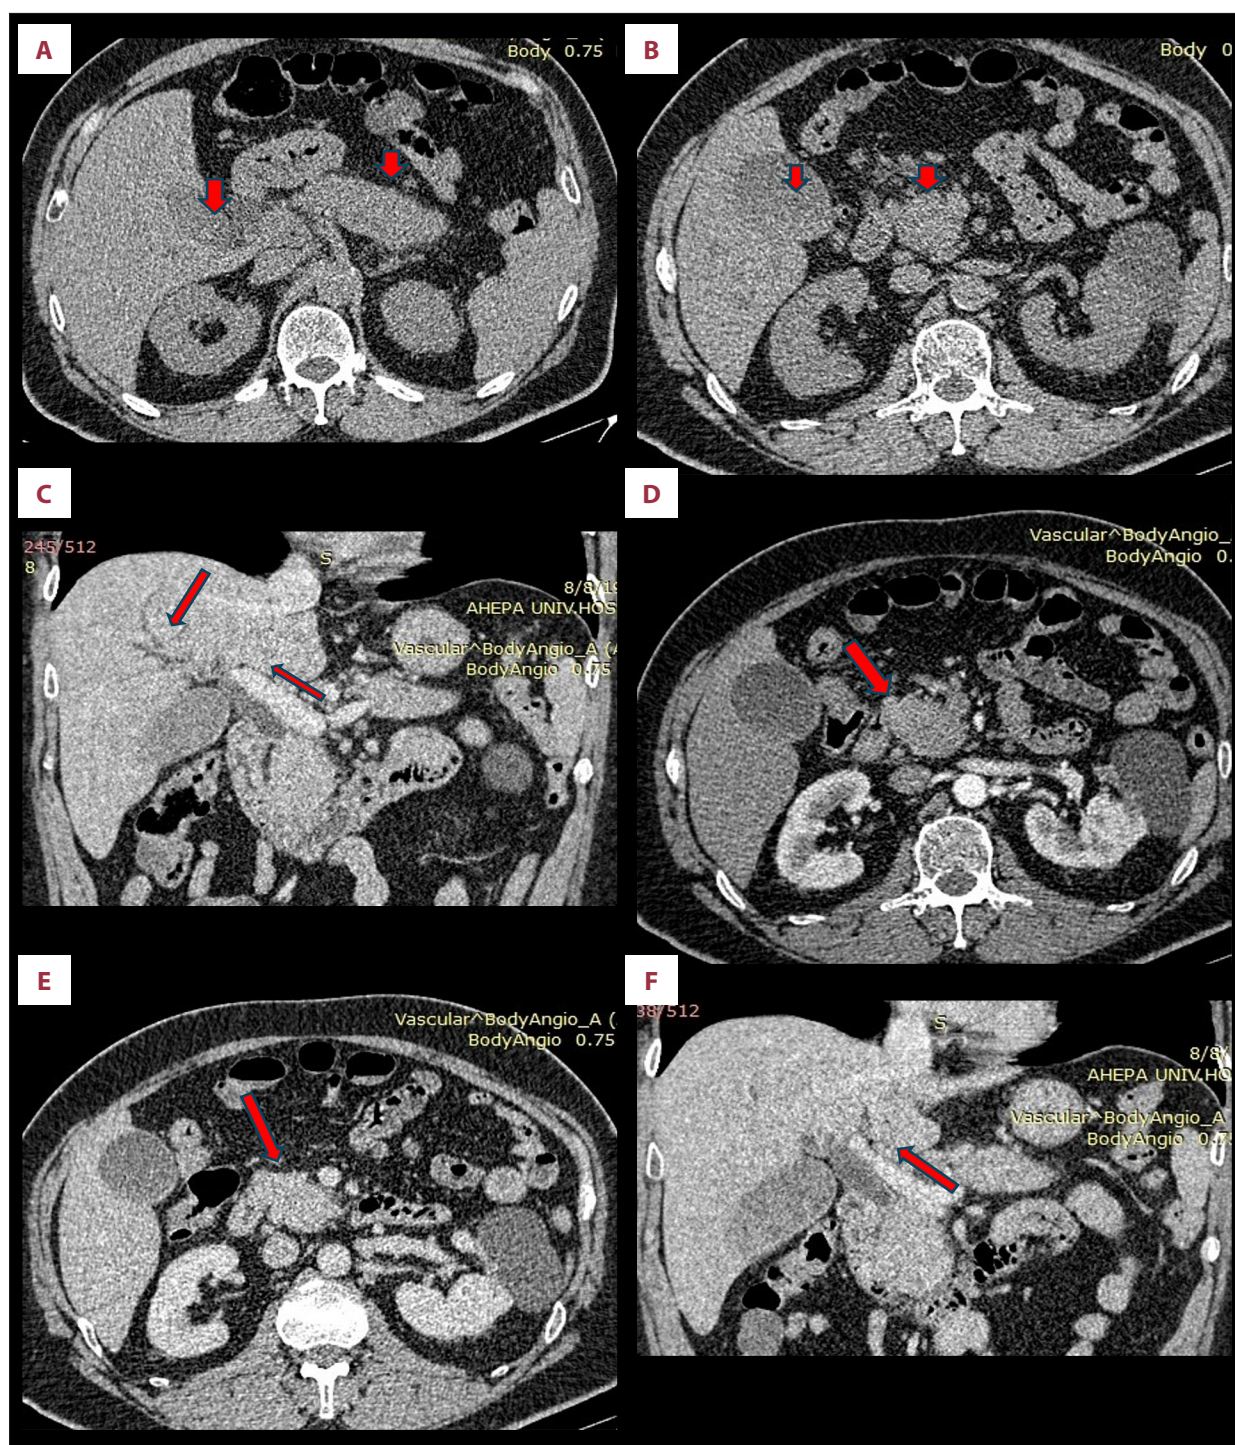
Detailed CT scan imaging characteristics of pancreatic enlargement and inflammation. (A, B) NECT axial images: Diffuse enlargement of the pancreas, especially of the head, with poorly-defined borders. Hyperdense content in the gallbladder. (C, D) CECT late arterial/portal venous phase; axial images: Heterogeneous attenuation of the head of the pancreas. Pancreatic inflammation is mainly localized to the area adjacent to the duodenum. Peripancreatic inflammation with surrounding fat stranding. (E, F) coronal and axial MPR images respectively: Pancreatic inflammation causing dilatation of the common bile duct and intrahepatic bile ducts. Arrows in the images point to the regions of inflammation and areas with ill-defined borders. NECT – non-enhanced computed tomography; CECT – contrast-enhanced computed tomography; MPR – multiplanar reconstruction.
